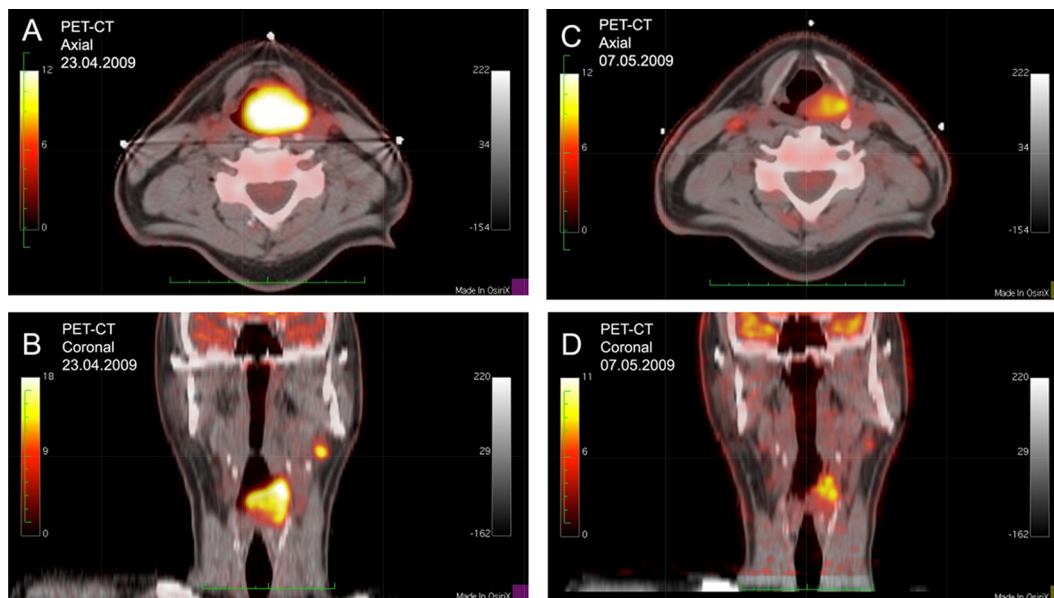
^{18}F FDG uptake before (A and B) and after (C and D) administration of 2 doses of CTX. The first ^{18}F FDG-PET/CT (axial (A) and coronal (B)) revealed pathological ^{18}F FDG uptake in the left side of hypopharynx and one lymph node in level II on the left side of the neck. The second ^{18}F FDG-PET/CT (axial (C) and coronal (D)) on 07.05.2009 showed significant decrease in ^{18}F FDG uptake in the tumor and the metastatic lymph node. SUV threshold value of 2.5 was used for image acquisition.
